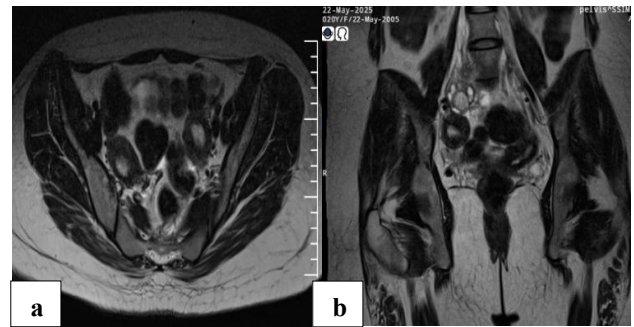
(a) Axial T2-weighted MRI showing two separate uterine horns consistent with uterine didelphys. Endometrial cavities are symmetric and appropriately distended for menstrual phase; and (b) coronal T2-weighted MRI showing uterine didelphys and vaginal canal without evidence of hematocolpos or obstructive anomalies.
